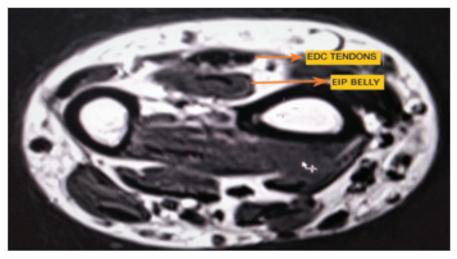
Transverse section at distal end of radius ulna showing belly of extensor indicis proprius (EIP) near the interosseous membrane (it is the only muscle belly to be present at that location, which is present in this MRI and extensor digitorum communis (EDC) tendons.
